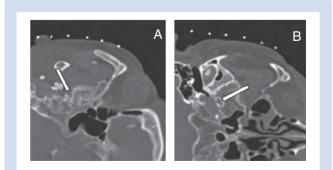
Axial CT sections of the head. (A) Gantry tilted. (B) Non-tilted. Arrow indicates the foramen ovale.
